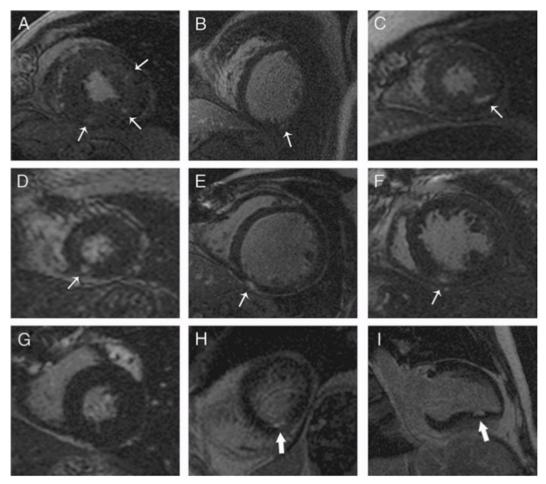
Delayed-enhanced MRI from different patients with severe AS¹¹²
